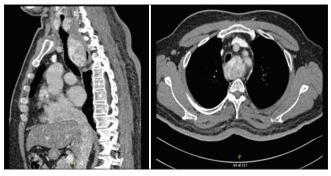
Computed tomography neck with contrast: Thyroid gland is diffusely heterogeneously enlarged with retropharyngeal extension of the left thyroid lobe into the retrotracheal location and tracheal compression extending into the arch of aorta level
